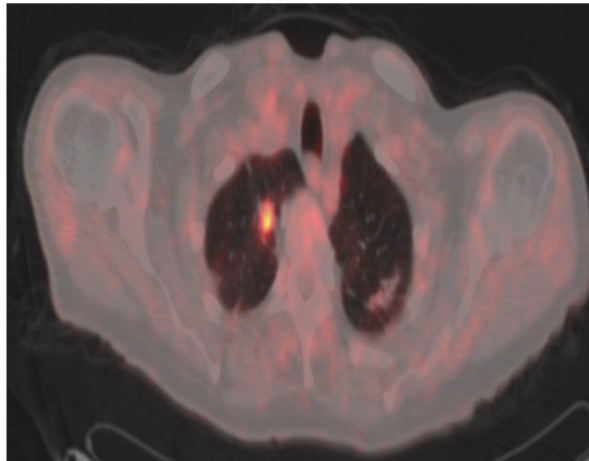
PET/CT revealing a 21x20 mm soft tissue lesion with a 12.41 SUVmax at the right upper lobe apical segment.
